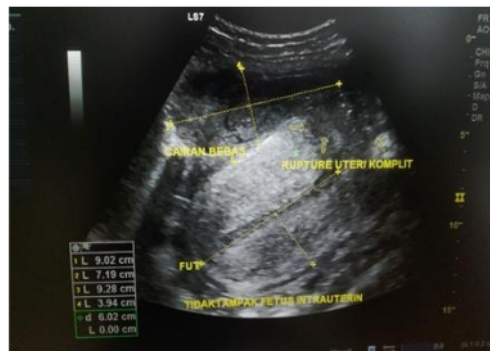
Ultrasound examination showed complete uterine rupture
